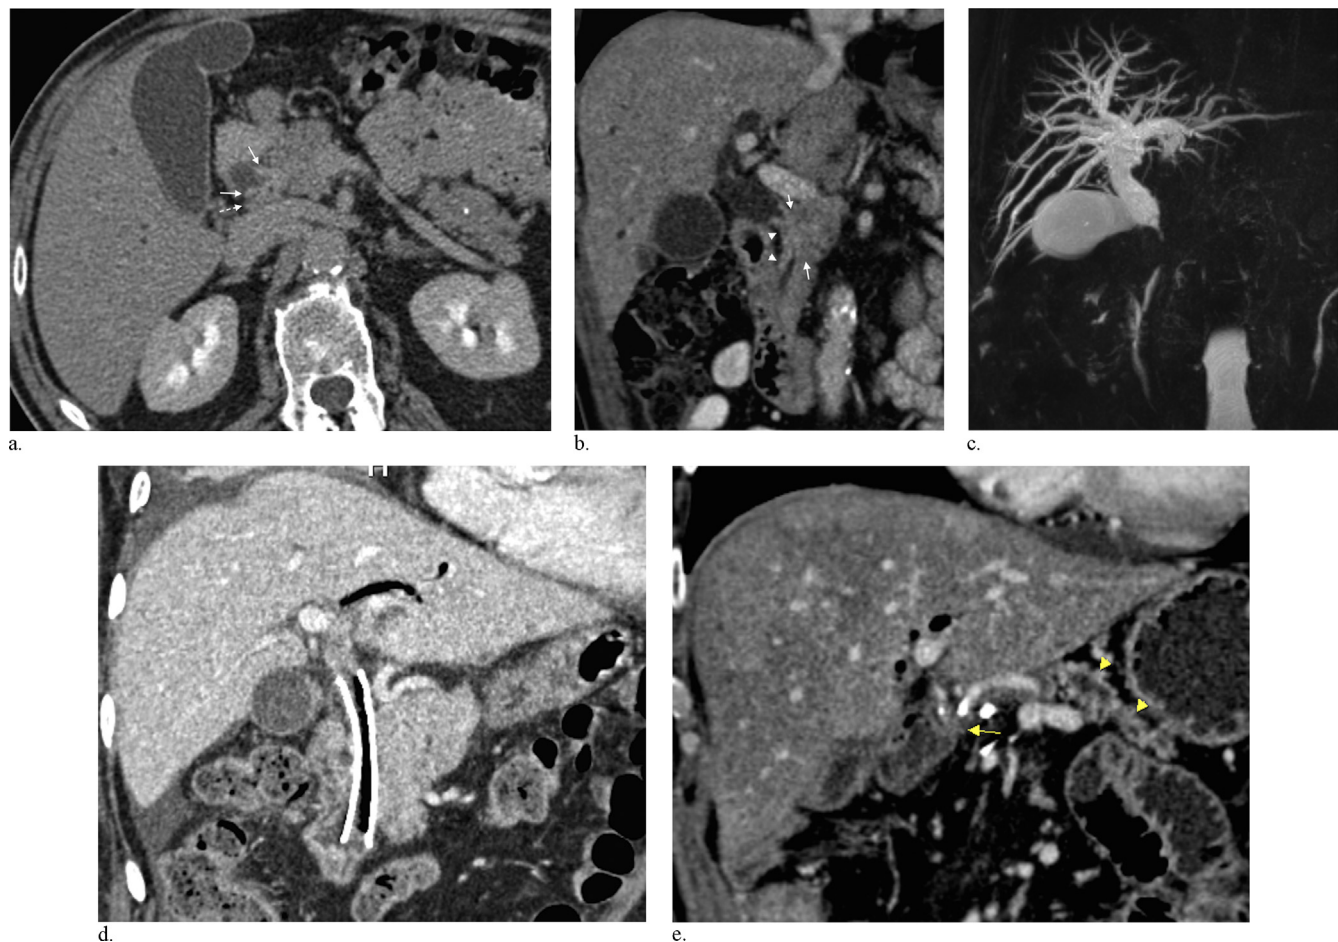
Images from a 67-year-old man referred with jaundice and recurrent cholangitis. (a) Axial CT image in delayed phase shows thickening of the distal CBD (solid arrows) with adjacent enlarged lymph node (dashed arrow). (b) CT coronal view shows that the thickened wall (arrowheads) is attached to the pancreatic parenchyma (arrows). (c) T2-weighted MR cholangiopancreatography sequence shows obstruction of the distal CBD and marked dilation of the intrahepatic bile ducts. The tumor was classified as stage IIA (T3N0M0). (d) CT coronal view shows the presence of a metallic stent within the mid-distal CBD after ERCP. Note that the stent has been placed distally to the hilum to allow resection. (e) Postsurgical coronal CT image shows the short biliary–jejunal anastomosis (arrow) and the remainder of the pancreas anastomosed to the jejunum, with dilated pancreatic duct (arrowheads).
